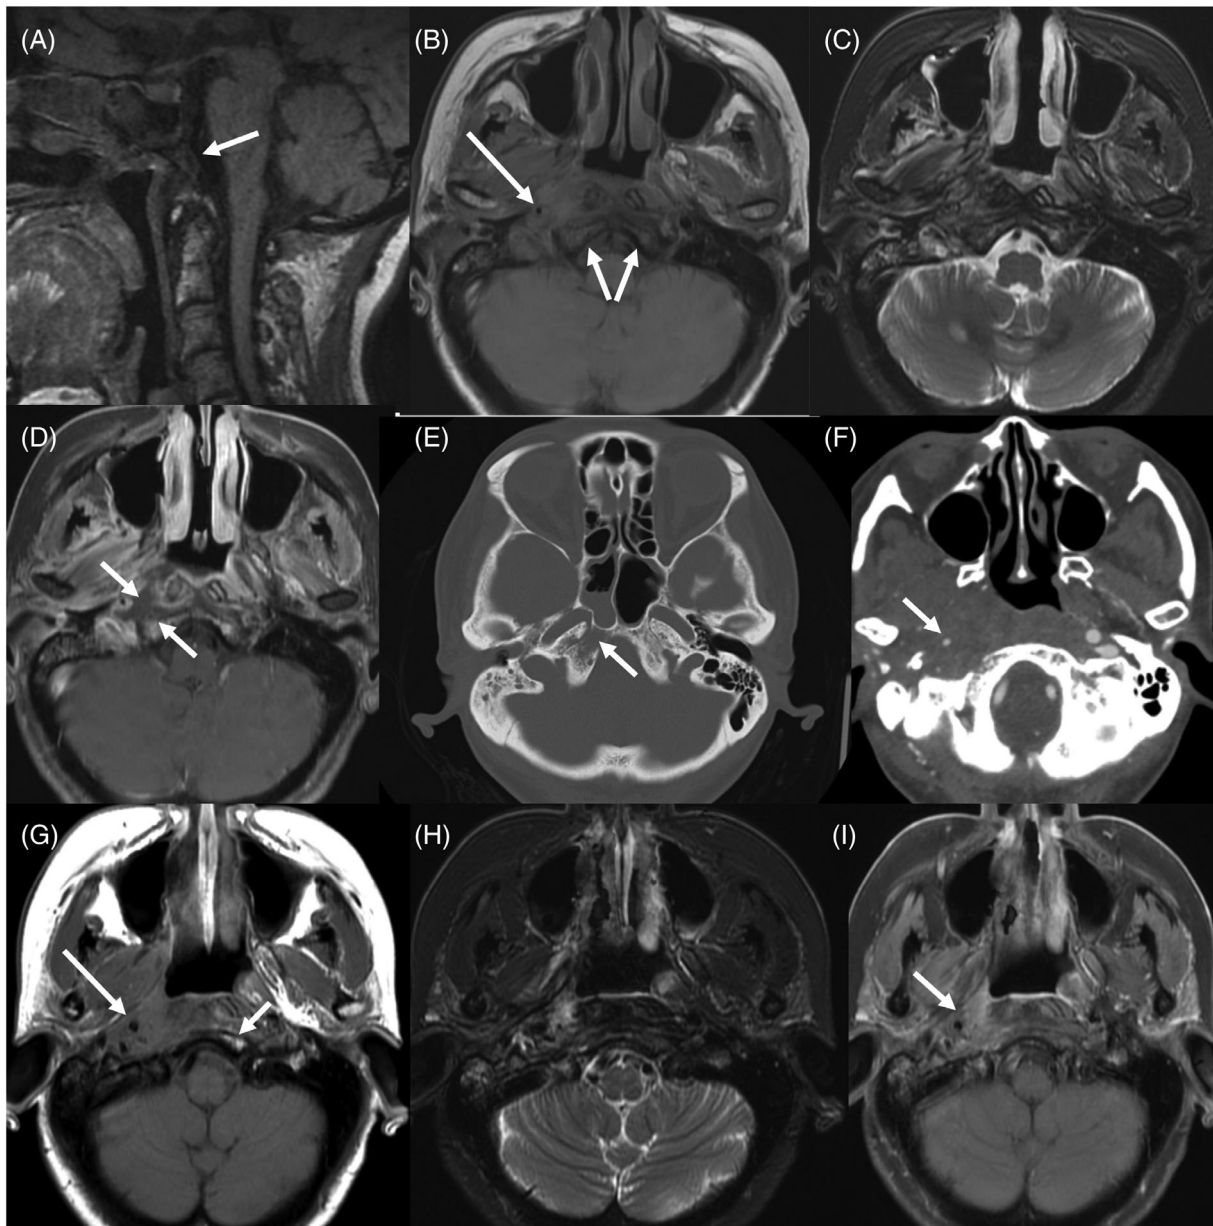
Representative MR images. 59-year-old female with nasopharyngeal carcinoma, treated with chemoradiation complicated by osteoradionecrosis, presented with worsening right ear and jaw pain, followed by otalgia and otorrhea, found to have skull base osteomyelitis (patient #23). (A) Sagittal T1-weighted image shows diffuse marrow hypointensity in the clivus (white arrow), which can be seen with tumor, osteoradionecrosis, and/or osteomyelitis. (B) Axial T1-weighted image shows diffuse loss of fatty marrow signal in the clivus (short arrows), as well as diffuse soft tissue thickening involving prevertebral, retropharyngeal, and parapharyngeal spaces, more so on the right. There is also marked narrowing of the flow void of the right internal carotid artery (long arrow). These findings are all suggestive of skull base osteomyelitis with adjacent soft tissue abnormalities. (C) Axial T2-weighted image with fat suppression also shows diffuse soft tissue and osseous signal abnormality without a focal mass, a finding that also supports infection rather than tumor recurrence. (D) Axial T1-weighted image, post gadolinium and with fat suppression, shows irregular nonenhancement consistent with infection and necrosis in the preclival soft tissues, again consistent with infection and radiation necrosis, which often go hand in hand. (E) Axial CT slice in bone algorithm shows focal erosion of the right side of the clivus (arrow), as well as fluid in the right sphenoid sinus and in the right mastoid and middle ear. (F) Axial image from a CT angiogram shows marked narrowing of the right internal carotid artery (arrow) as well as again demonstrating diffuse thickening of the preclival soft tissues and subtle right clival erosion. (G) Axial T1-weighted image from a follow up MR obtained almost 2 years later shows marked improvement in prevertebral soft tissue thickening, clival marrow (short arrow indicates fatty marrow signal in the left clivus), and improvement in the caliber of the right internal carotid artery (long arrow). (H) Axial T2-weighted image with fat suppression shows near resolution of the previously seen diffuse soft tissue thickening and edema. (I) Axial T1-weighted image, post gadolinium and with fat suppression, shows resolution of the areas of previously identified soft tissue necrosis. Only mild residual enhancing tissue remains (arrow), which is nonspecific and may represent granulation tissue, fibrosis, and scar. Though the presence of residual viable tumor is difficult to exclude, there are no findings to specifically point to tumor recurrence or active infection
